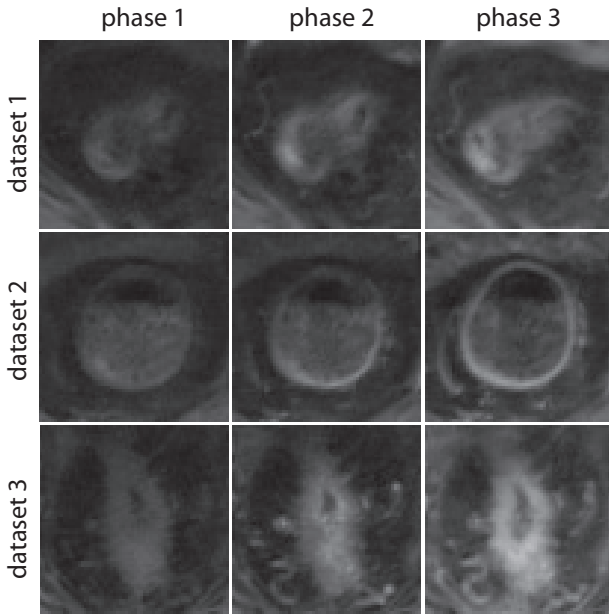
Three DCE-MRI datasets of rectal tumors shown at three characteristic phases: pre-contrast (column 1), begin of contrast-enhancement (column 2), contrast-enhanced (column 3).
